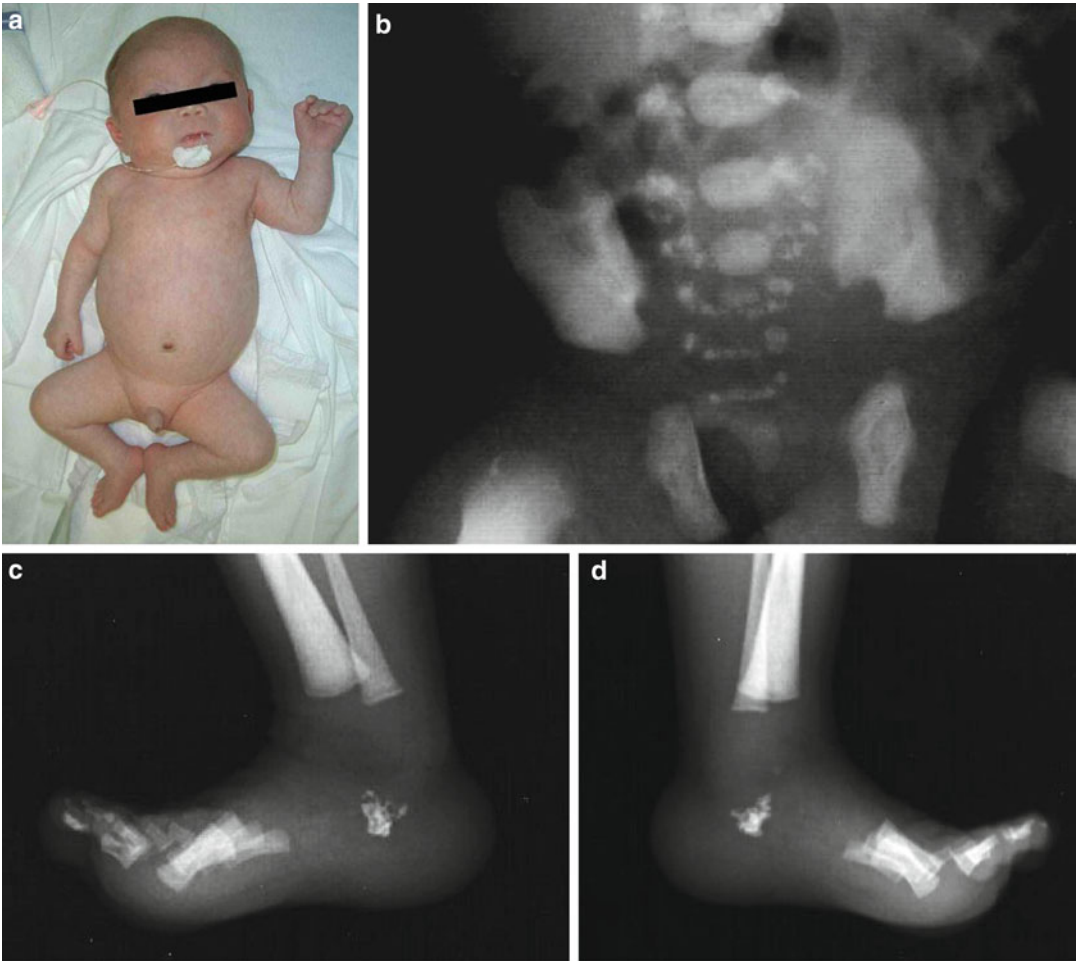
(a–d) Patient 1 (a Japanese newborn boy) with X-linked recessive form of chondrodysplasia punctata. Radiographs show paravertebral and calcaneus punctate calcification
